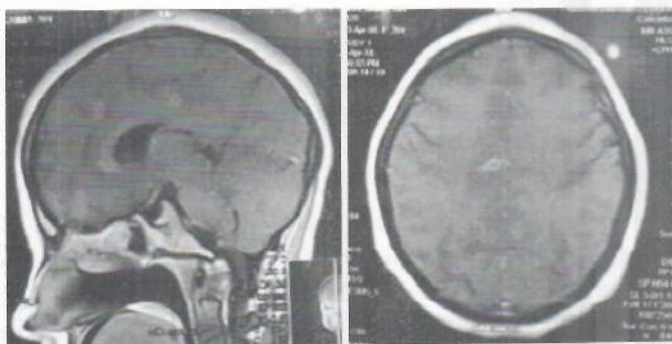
MRI Showing Tuberculoma
